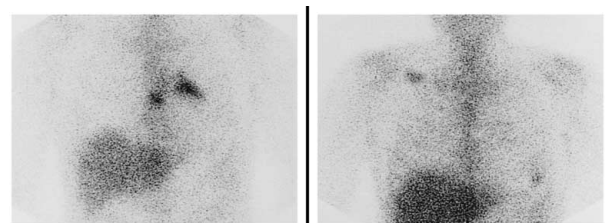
Gallium scintigraphy on admission (Left panel) and 6 months after 4 cycles of treatment with rituximab (Right panel). The abnormal uptake seen in the left and right sides of the heart on admission had almost disappeared after the treatment.
